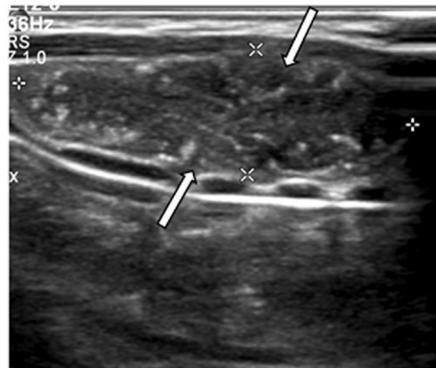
A 44-year-old woman with a clinically suspected thyroid nodule. (a) Transverse and (b) longitudinal gray-scale ultrasound show a nodule at right thyroid lobe (arrows). The nodule is solid, very hypoechoic, wider-than-tall, and has a smooth margin. (c) Longitudinal color Doppler ultrasonography (not part of TI-RADS) shows marked intranodular vascularity (arrow). The nodule was categorized as TR4. Cytology shows follicular thyroid adenoma.
